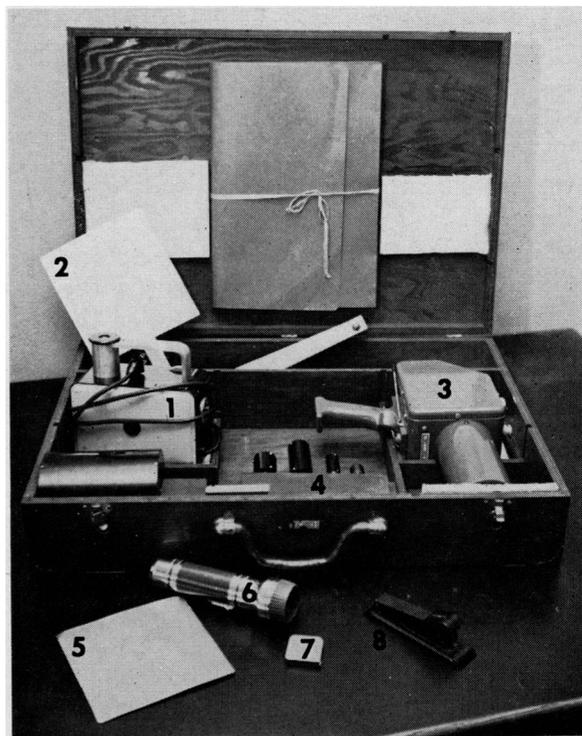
X-ray survey kit used by the Oregon Health Department
